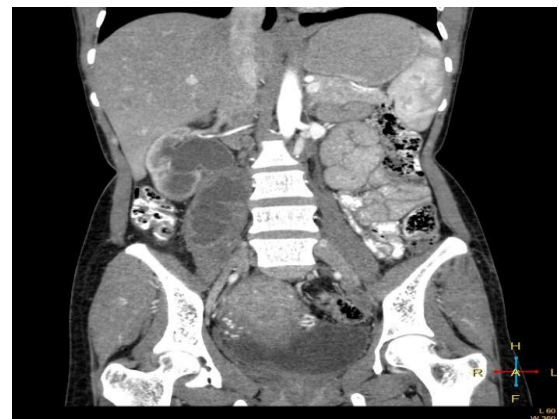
Contrast enhanced coronal CT section showing extent of abscess involvement. The abscess is seen extending from L2-L5 and closely abutting right PUJ and proximal ureter.
